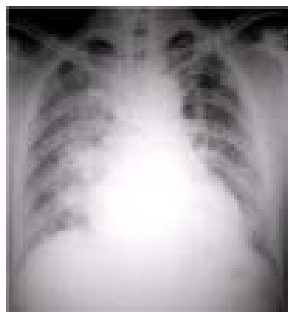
Chest Radiograph Shows Cardiomegaly & CHF
